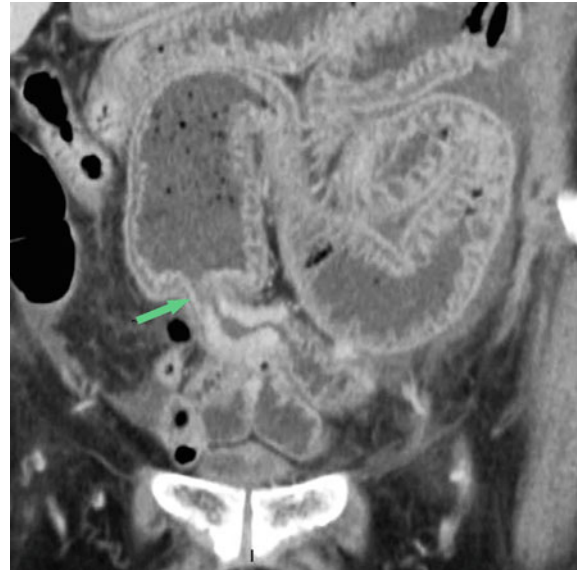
Mechanical small-bowel obstruction on CT performed 14 days after appendectomy associated with peritonitis in a 34-year-old man
